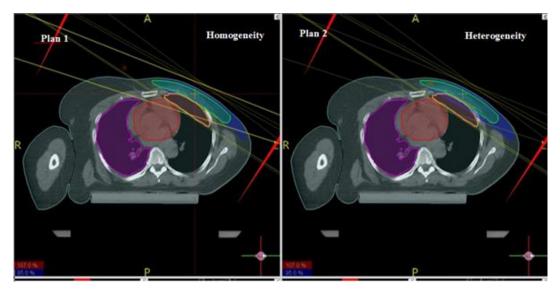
Computed tomography cuts with isodose distribution curves using 6 MV with the same beam configuration. The green color shows the planning target volume and the blue color shows 95% isodose line
